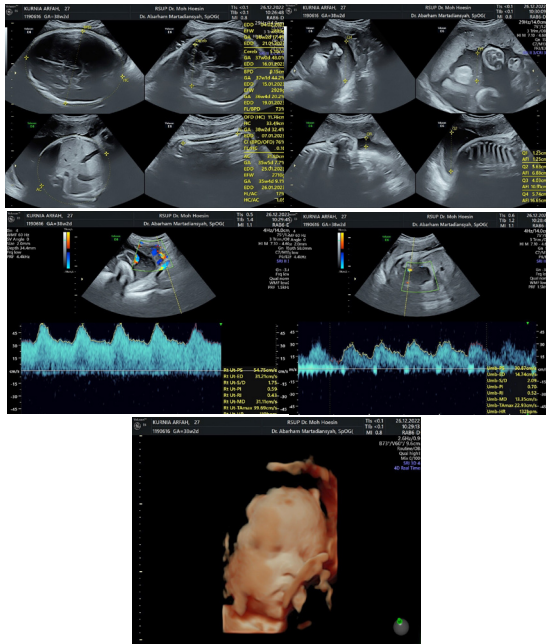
Ultrasound at 37 Weeks of Pregnancy Single Fetus Head Presentation
